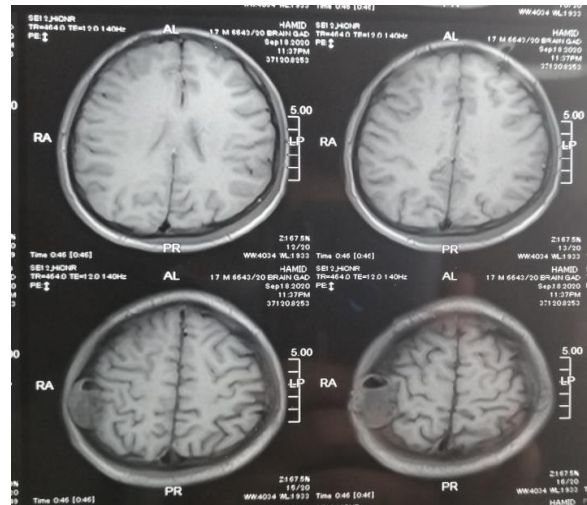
MRI brain (Axial T1WI) showing a hypointense lesion within right parietal bone.
